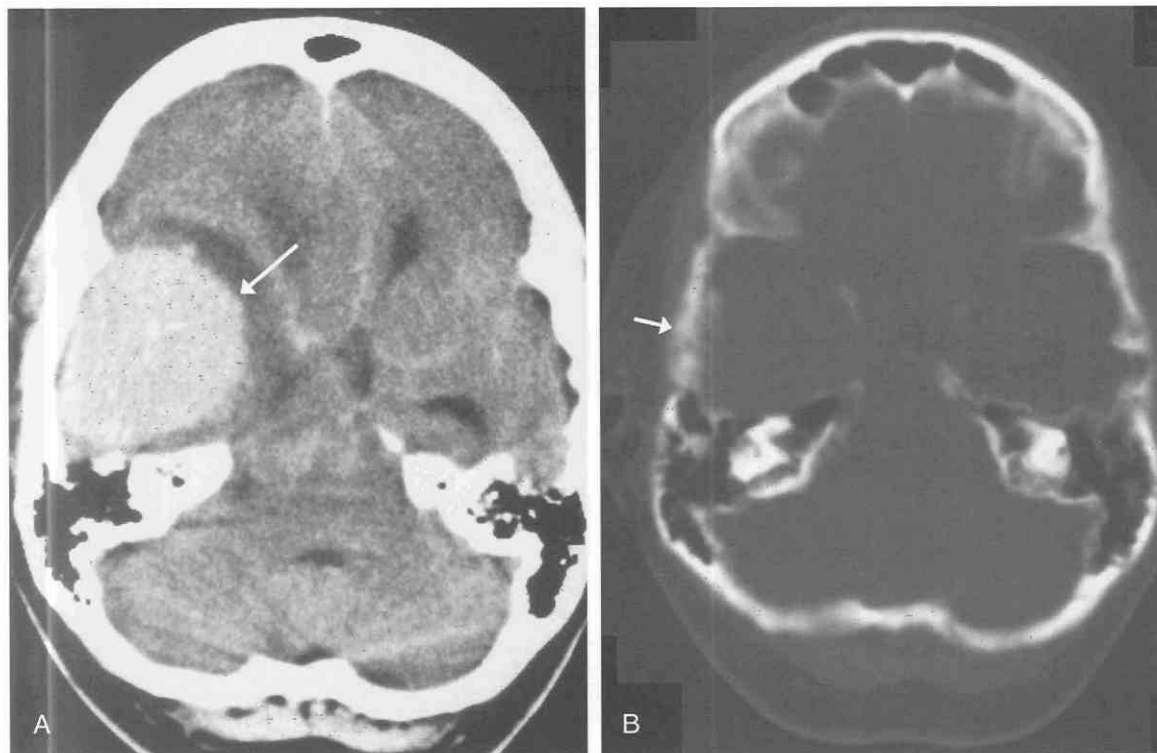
Sphenoid wing meningioma with underlying hyperostosis (“meningioma bone”). *A*, Axial postcontrast CT image demonstrates intense homogeneous contrast enhancement of a large round extracerebral tumor with its base on the right greater sphenoid wing (arrow). On its inner aspect, the tumor is surrounded by a thick band of hypodensity representing edema of the adjacent cerebral cortex and white matter. There is a marked shift of the midline vessels to the left. *B*, On an axial CT image displayed in a bone window setting, the underlying greater sphenoid wing and squamous portion of the temporal bone demonstrate heterogeneous bony thickening (arrow).
